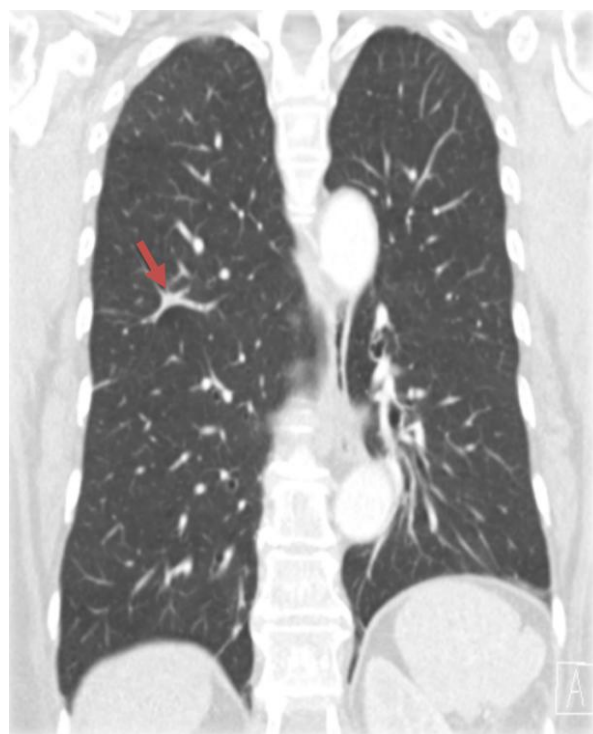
A coronal CT scan in 2017, after 10 years of therapy showed minimal scar tissue in the right upper lobe, which is considered as a complete resolution (arrow).
